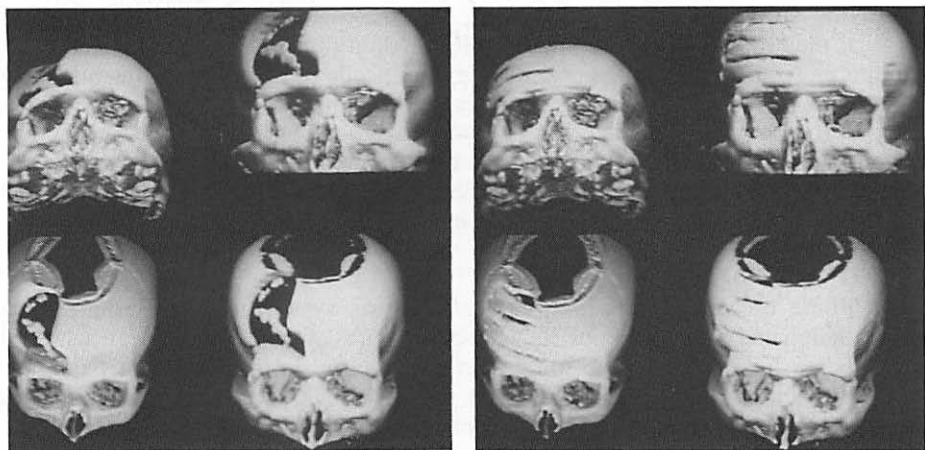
3D display of the skull reconstructed from Computed Tomography images before (left) and after (right) operation.
